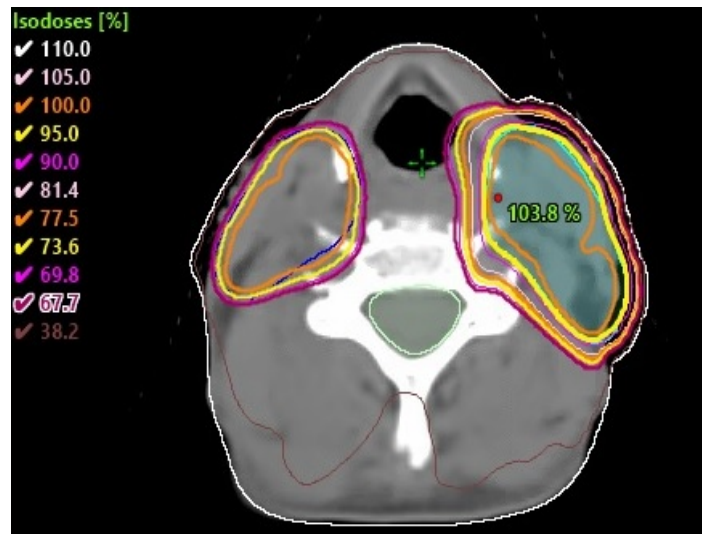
Dose distribution of patient 3 in a balanced treatment plan created in Eclipse. The figure shows the sagittal CT image of the patient and the structures of PTVT (light blue), PTVN (dark blue) and PRV spinal cord (green). For PTVT, the goal is for the 95%-isodose to cover 98% of the volume of PTVT. For PTVN, the goal is for the 73.6%-isodose to cover 98% of the volume of PTVN.
